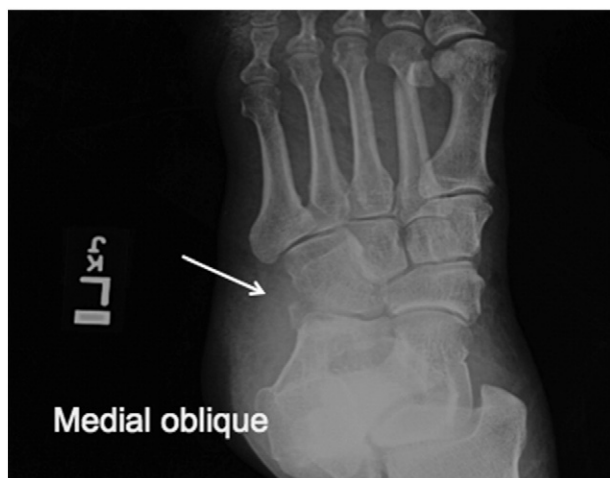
Oblique radiograph of the left foot depicts cuboid avulsion fracture (arrow) at the insertion of the plantar calcaneocuboid ligament.
